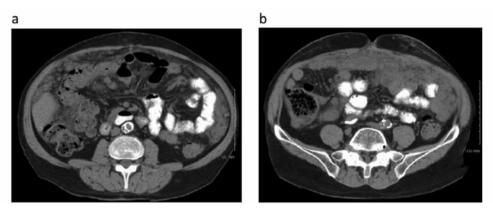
CT scans of the abdomen showing resolution of pneumatosis intestinalis of the right and transverse colon.
